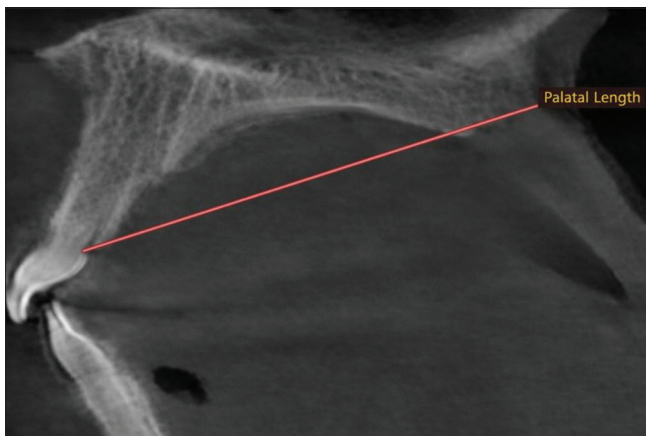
Cone-beam computed tomography sagittal view showing the linear distance measurement of palatal length
